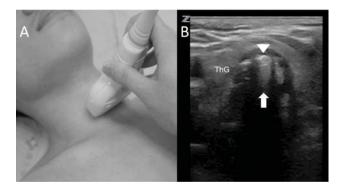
(A) Placement of a linear ultrasound transducer in a transverse orientation on the anterior neck just superior to the suprasternal notch. (B) Ultrasonographic image of normal trachea. The sonogram shows the trachea, thyroid gland, A–M interface (arrowhead), and the comet-tail artifact (arrow). ThG= thyroid gland
